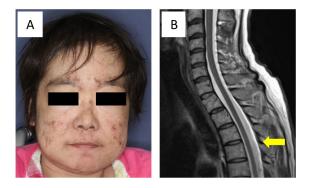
(A) Discrete maculopapular erythema on her face. (B) Magnetic resonance imaging (MRI) showed an atrophy of whole thoracic spinal cord.
